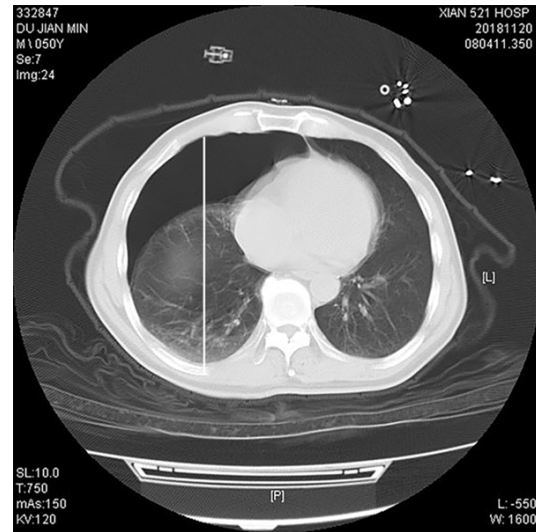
Maximum anteroposterior diameter (D value) of the transdiaphragmatic thorax (white line) in CT image.
